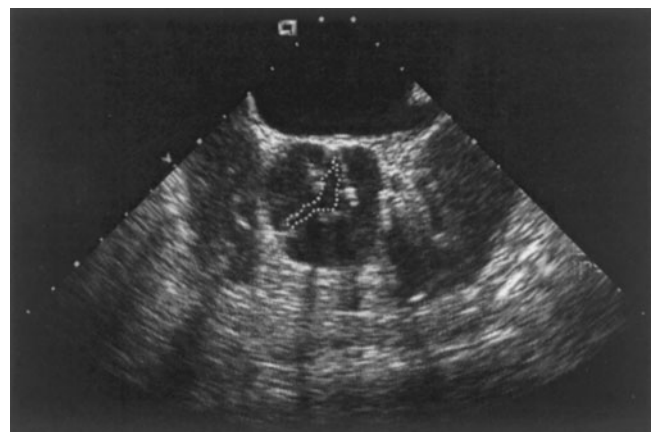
Transesophageal echocardiographic image of severely calcified aortic stenosis. Dotted lines highlight the significantly reduced aortic valve orifice.
